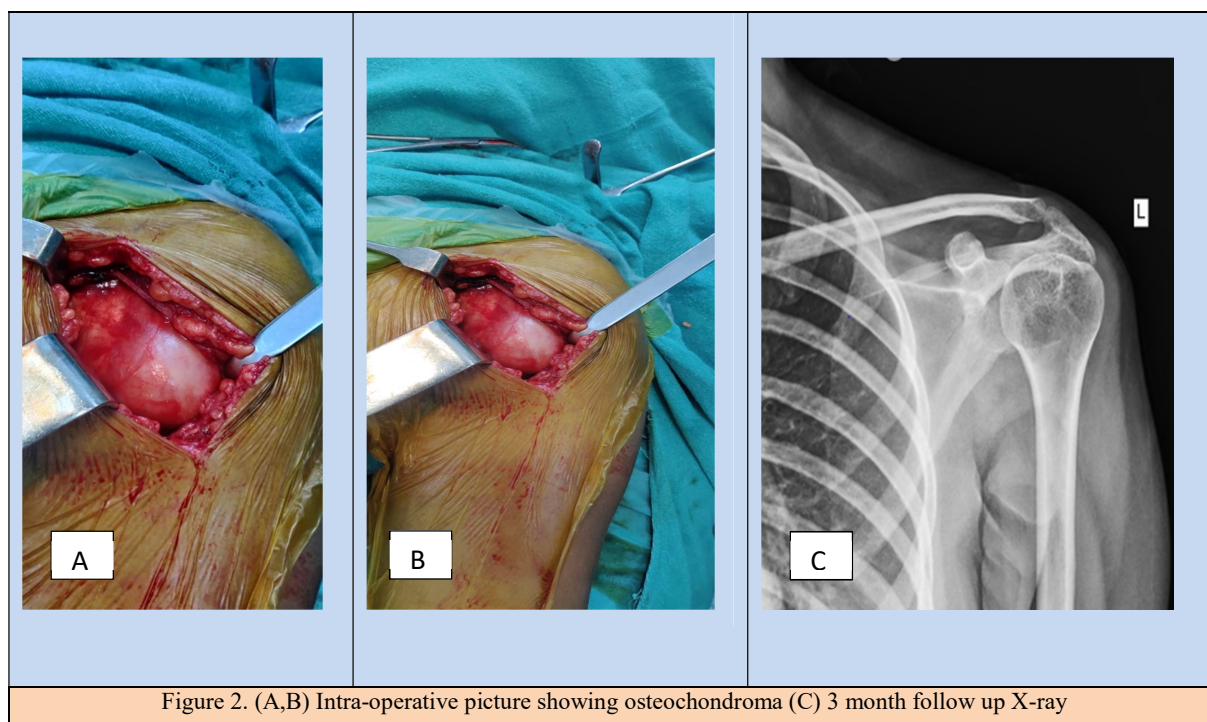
(A,B) Intra-operative picture showing osteochondroma (C) 3 month follow up X-ray
